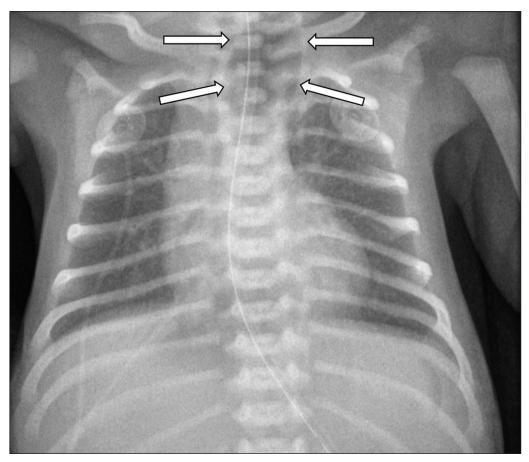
Thoracic X-ray shows a progressive widening air column (white arrows) projecting on the cervicothoracic region.
